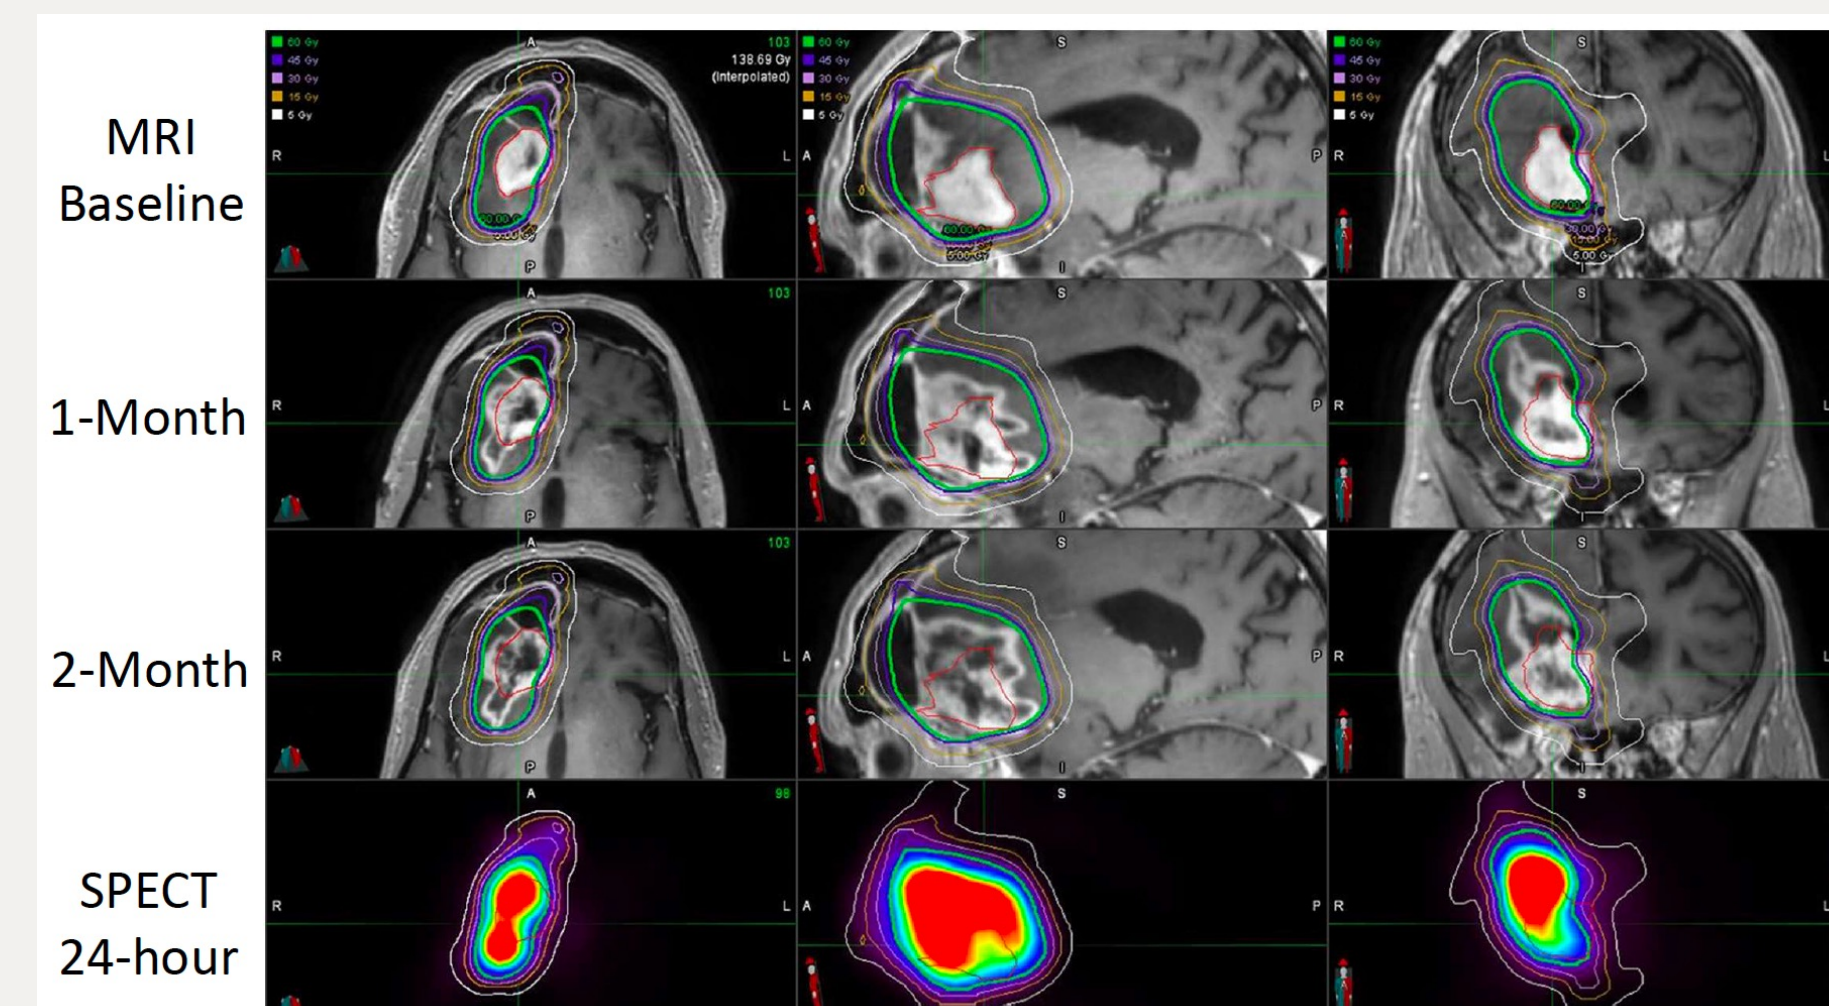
Pretreatment MRI, post treatment MRIs (1 and 2 months), and SPECT (24-hours post treatment). Patient is still alive at time of reporting, with OS of 273 days.
